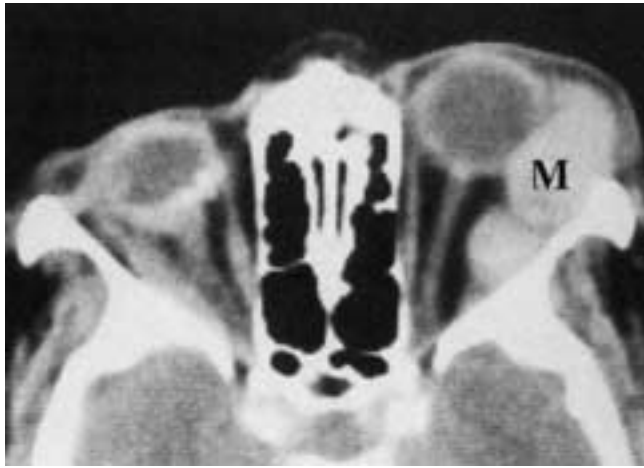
Fibrous histiocytoma. Axial postcontrast CT scan showing a bilobed enhancing mass (*M*) involving the peripheral orbital space. Notice the deformity of the right globe with calcifications representing pthisis bulbi. (From Mafee MF et al. Orbital space-occupying lesions: role of CT and MRI: an analysis of 145 cases. *Radiol Clin North Am* 1987;25:529–559.)
